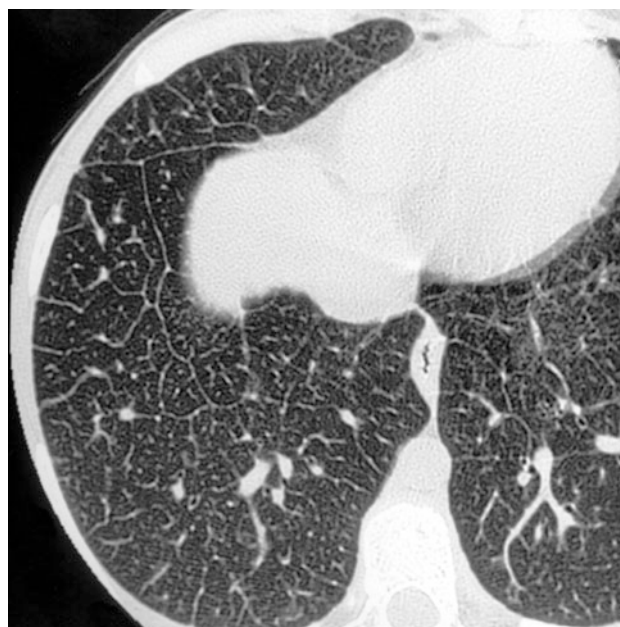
An 11-year-old-girl with hemosiderosis. HRCT shows ground-glass attenuation and air cysts, involving subpleural regions
